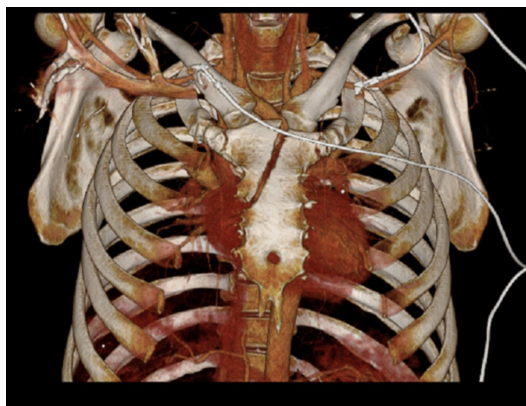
Three-dimensional reconstruction of chest CT showing oblique fracture through a congenitally fused sternum.
